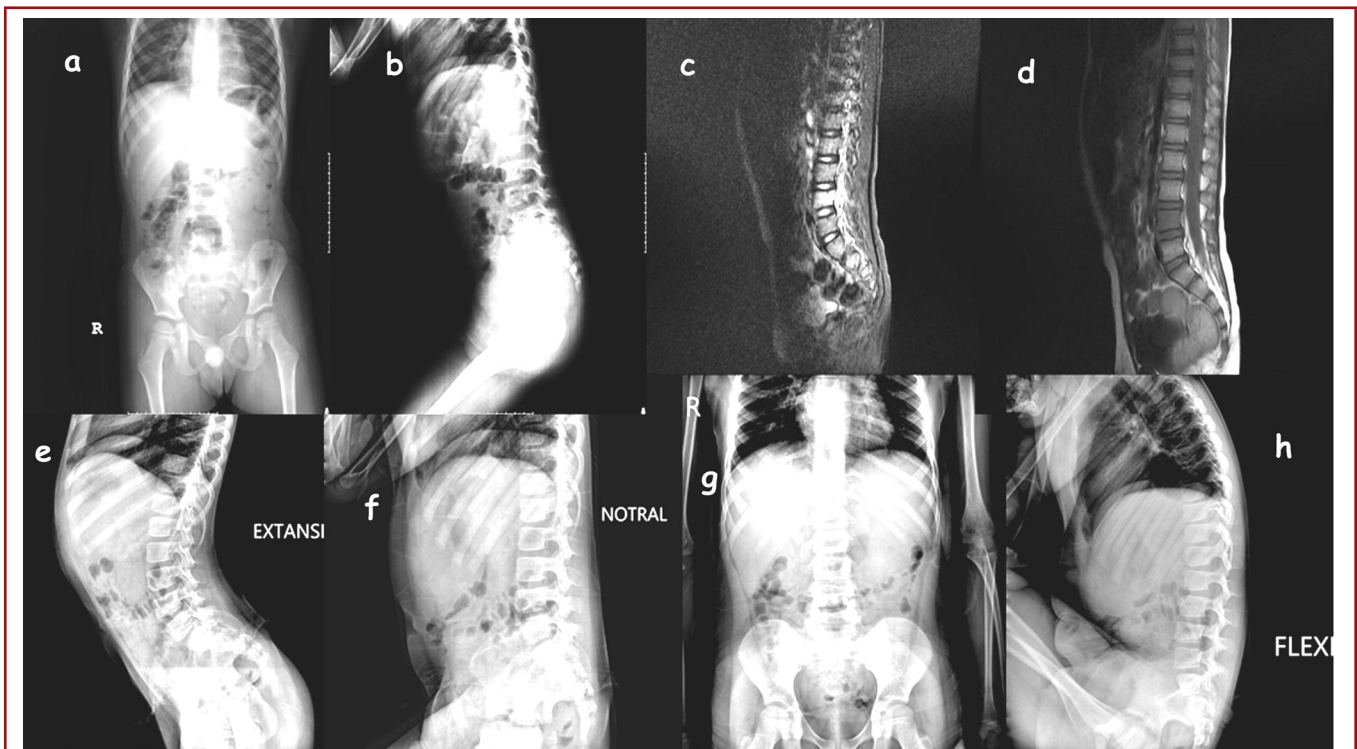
a) First AP and b) lateral x-rays taken in ER. Signs of fracture were not determined. c-d) In the MRI (STIR) of the patients L-4 fracture was shown. e) Post-treatment AP and f) lateral, g) extension and h) flexion x-rays in 3rd years control visit after trauma.
